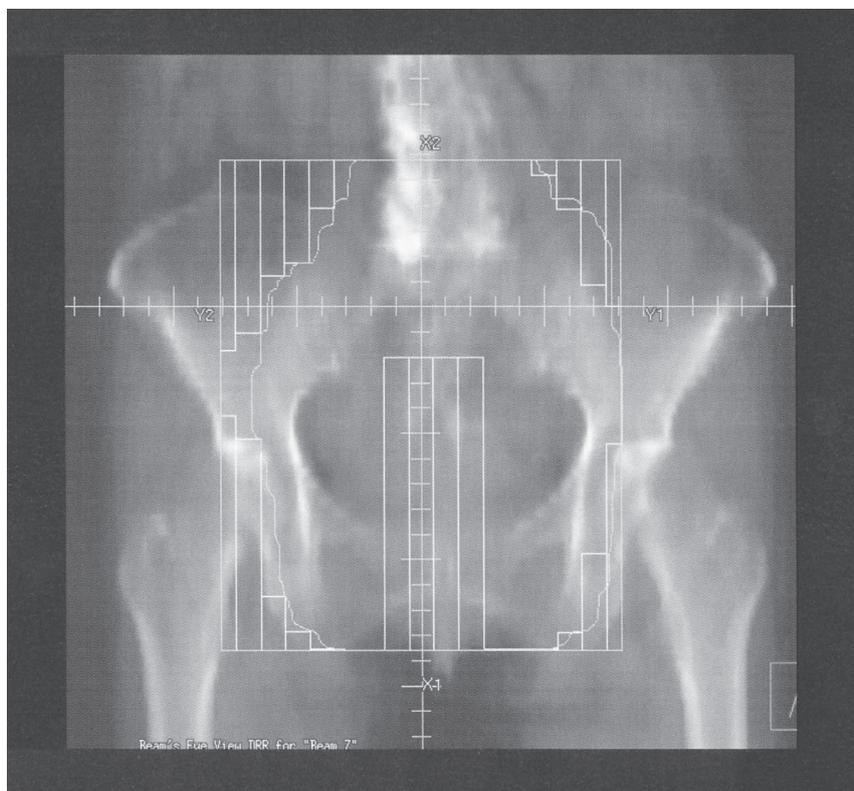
Digitally reconstructed radiographic image of the center shield field.
